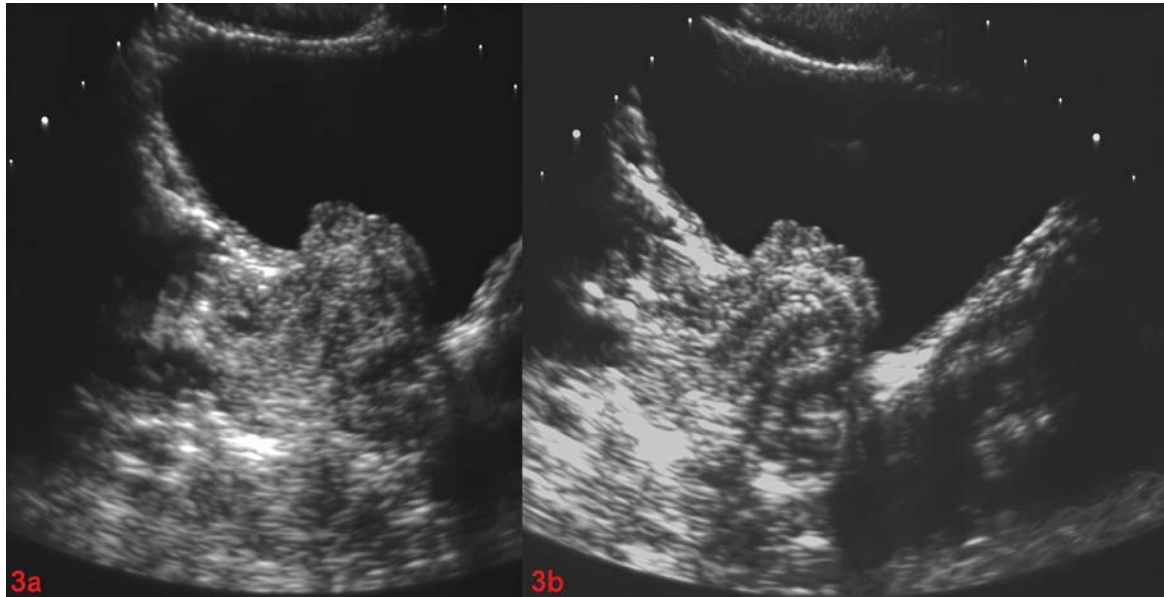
a-b Axial sonograms which show a peculiar mass projecting into the urinary bladder. We can depict the helical configuration of the internal structure which means that something wrong has happened embryologically in the metanephric blastema
